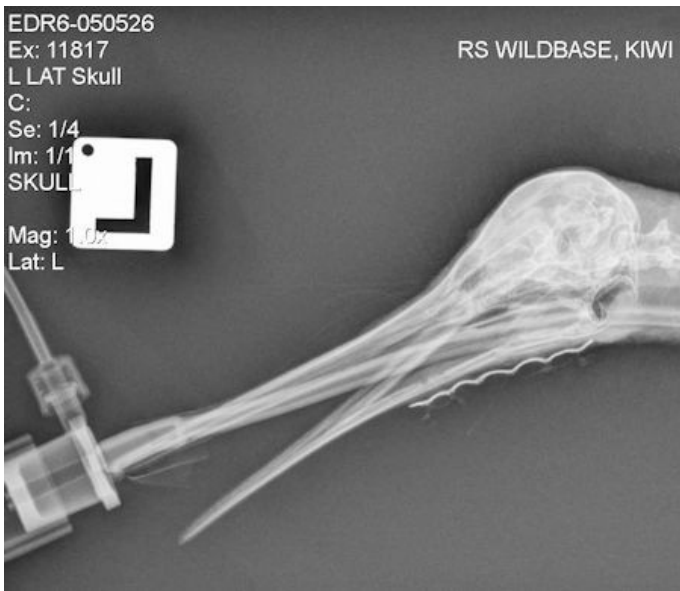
Left Lateral oblique radiograph with external splint device held in place with circumferential sutures
